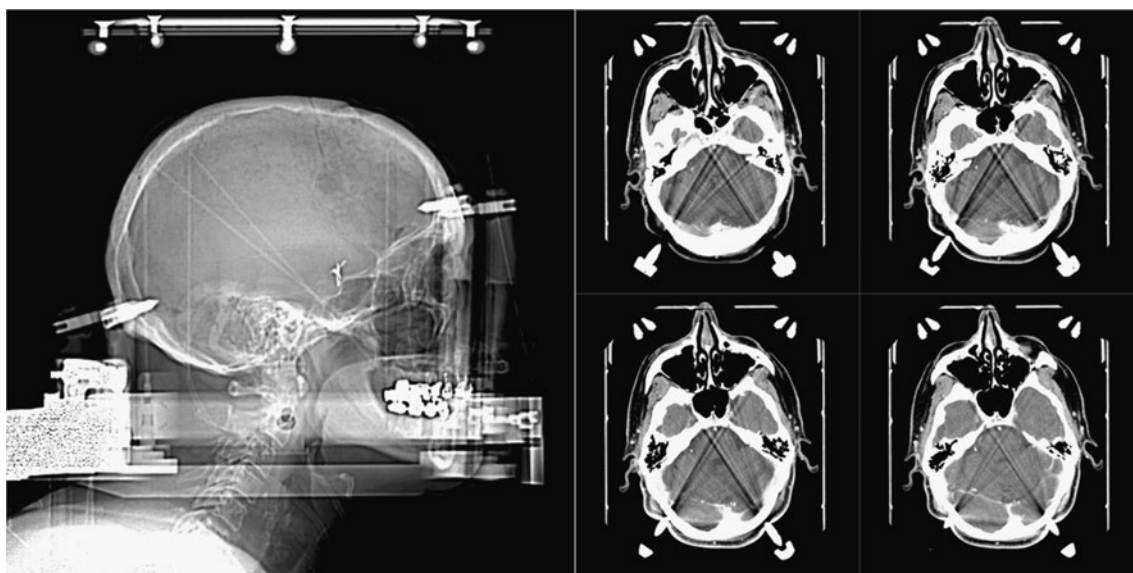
Computed tomography demonstrating the pin-related artifact (case 10). Posterior pin was located too close to the inion (a), which caused artifact in the region of the trigeminal nerve (b)
